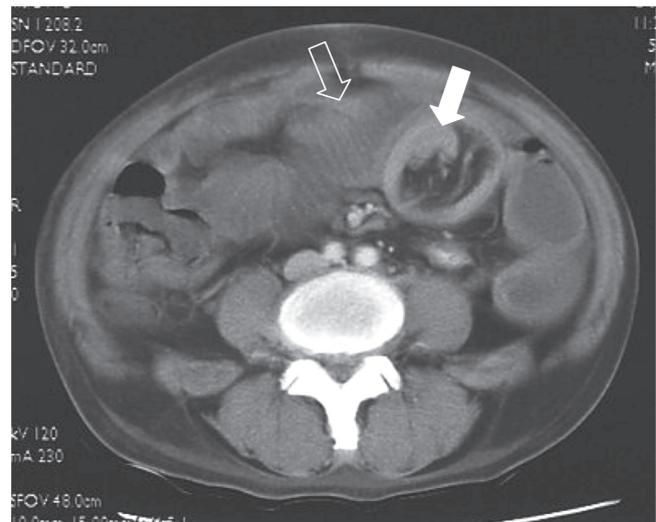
Abdominal CT scan. White open arrow indicates dilated loops of small bowel with typical coiled-spring appearance. White closed arrow shows the polypoid lead point of the intussusception.
